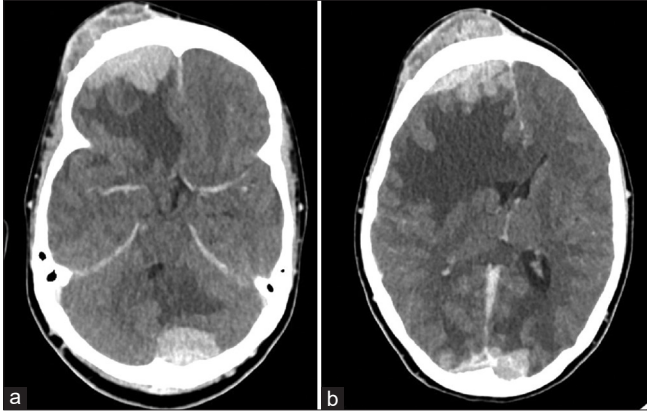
Contrast-enhanced computed tomography head – (a and b) axial cuts – showing contrast-enhancing lesion in the right frontal region with extension into extra calvarial space with perilesional edema and another similar lesion in the posterior fossa with mass effect.
